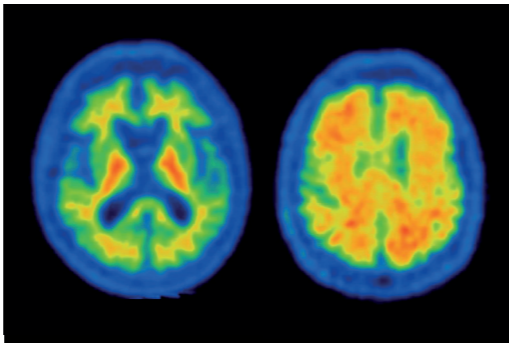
3T-MRI with corresponding (18F-Flutemetamol) Amyloid-PET-Scan; left: Amyloid negative imaging of a cognitively healthy patient; right: Amyloid positive imaging of patient with AD.
